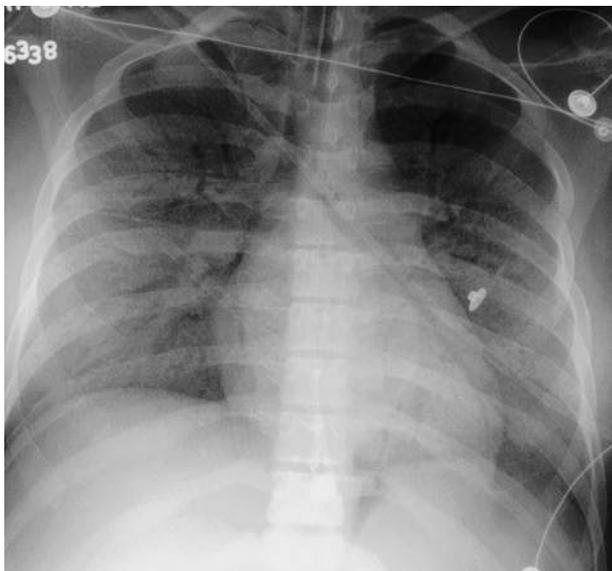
Air bronchograms. This portable radiograph shows diffuse increased density throughout both lungs highlighted by tubular lucencies. These are air bronchograms. They are visualized because of the alveolar filling that surrounds them. This typical alveolar filling pattern (airspace disease) suggests acute pneumonia, pulmonary hemorrhage, or pulmonary edema.
